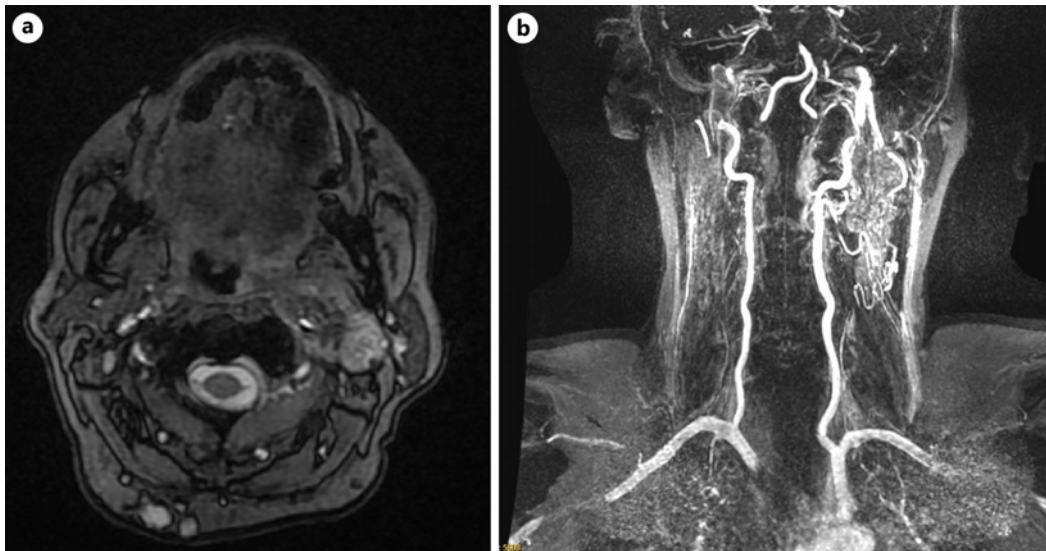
a Magnetic resonance imaging of the cervical region at time of diagnosis, showing a round neoplasm of 65 mm × 37 mm, in the left carotid space which laterally displaces the jugular vein and encompasses the carotid artery, both vessels maintaining its permeability. It has intense uptake of contrast in T2. b Vascular reconstruction of the neoplasm which predominantly irrigates from left vertebral artery.
